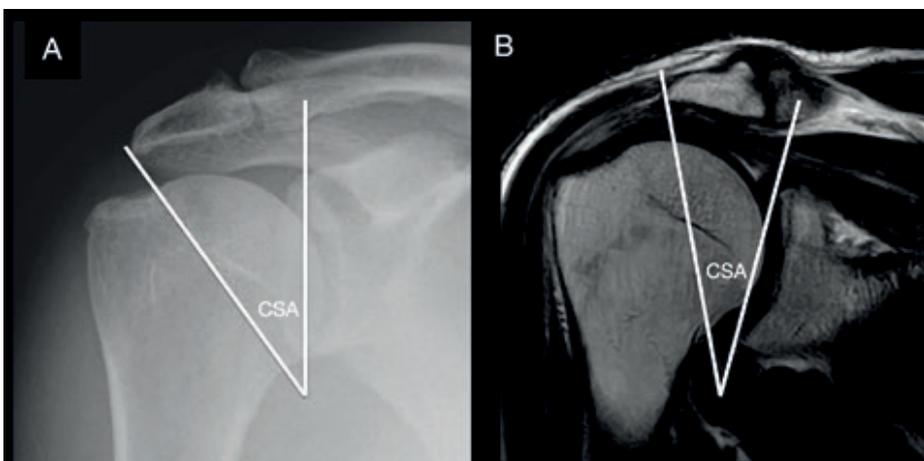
The critical shoulder angle (CSA) is measured on true AP radiographs or coronal MRI scan and corresponds to the angle formed between the glenoid plane and a line connecting the inferior glenoid rim with the lateral aspect of the acromion. A high CSA is associated with rotator cuff tears
